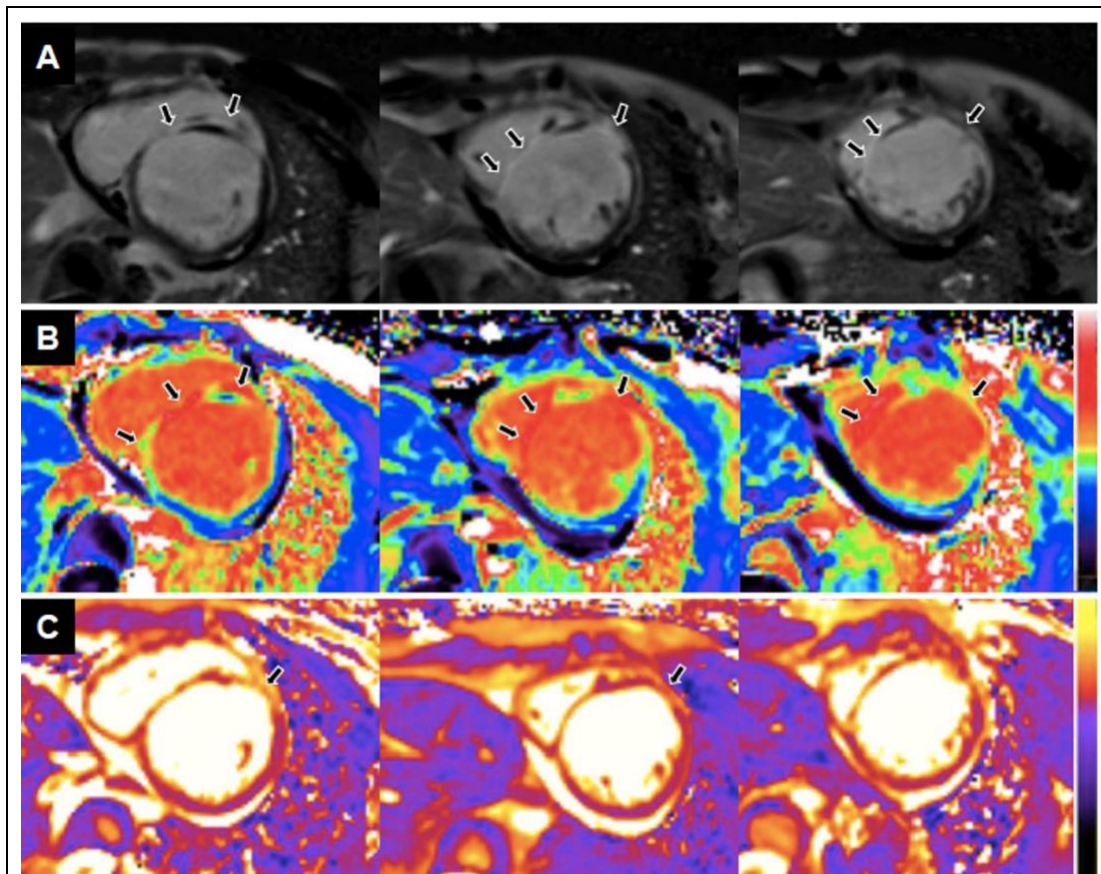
Cardiac magnetic resonance imaging. (A): Late Gadolinium Enhancement (LGE) short-axis images showing subepicardial and transmural scarring in the basal to mid interventricular septum and transmural and subendocardial in the mid and apical anterior wall (arrows); (B): Extracellular volume (ECV) maps and (C): T2 maps of corresponding stacks showing increased ECV and T2 values in the septum and anterior wall (arrows). Figures from Dr. Göran Abdullah, Clinical physiology, Region Stockholm.
